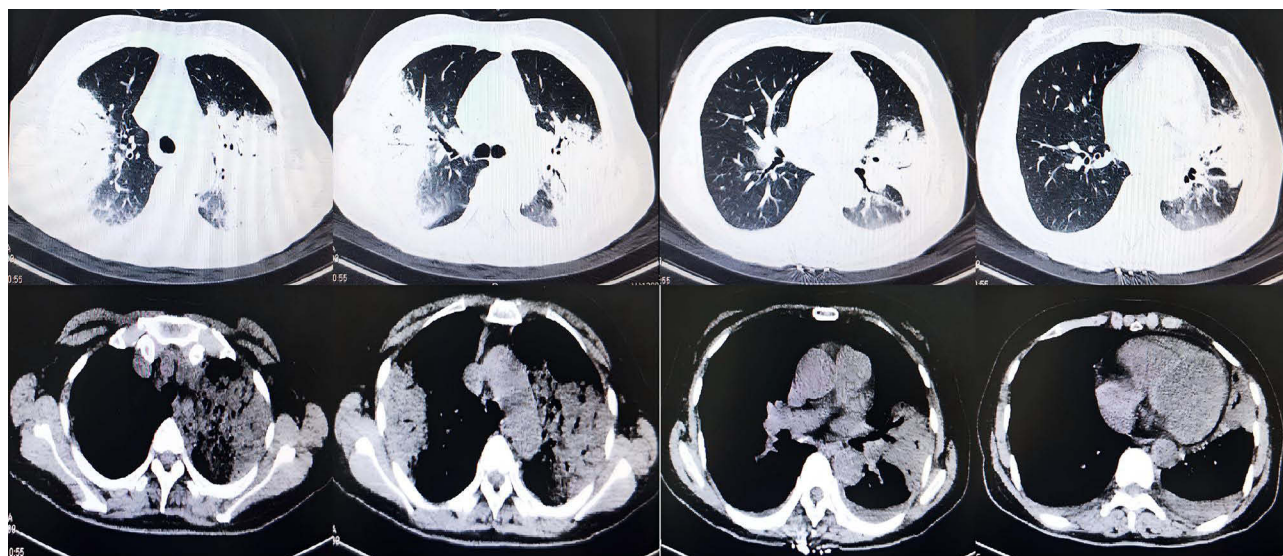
Multiple patchy high-density shadows and consolidation shadows of both lungs (CT image of the chest on 3th day before admission).
